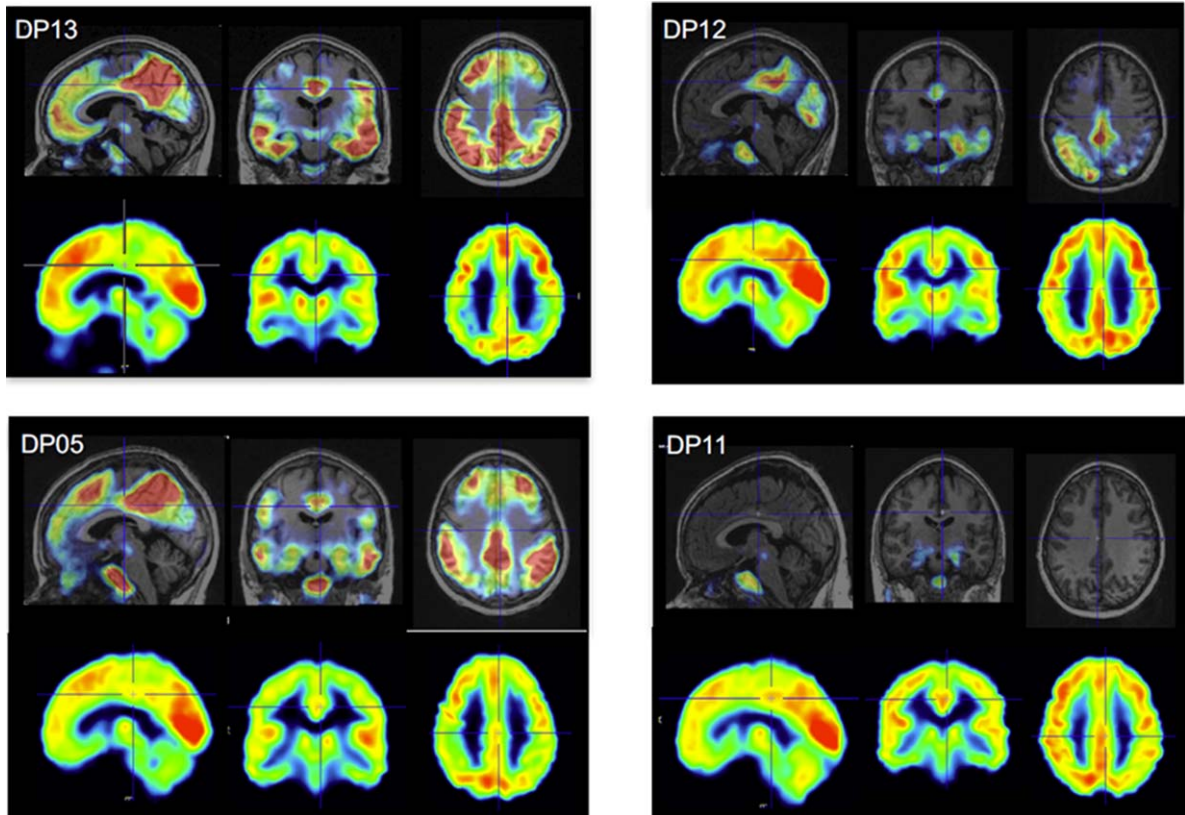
Tau PET distributions (upper rows) and FDG PET images (lower rows) for four example amyloid positive subjects. In general, hypometabolism in FDG (light yellow/green rather than red) is consistent with the tau accumulation shown in red. This includes posterior cingulate and precuneus hypometabolism in subjects DP05 and DP13, and asymmetrical deposition and hypometabolism seen in subject DP12 parietal cortex and DP13 frontal cortex. However, even when tau is limited to early stages, subjects have hypometabolism as seen in DP11, which arises partially from Down syndrome and is dissociated from the effects of AD by the machine learning classifiers in this work.
